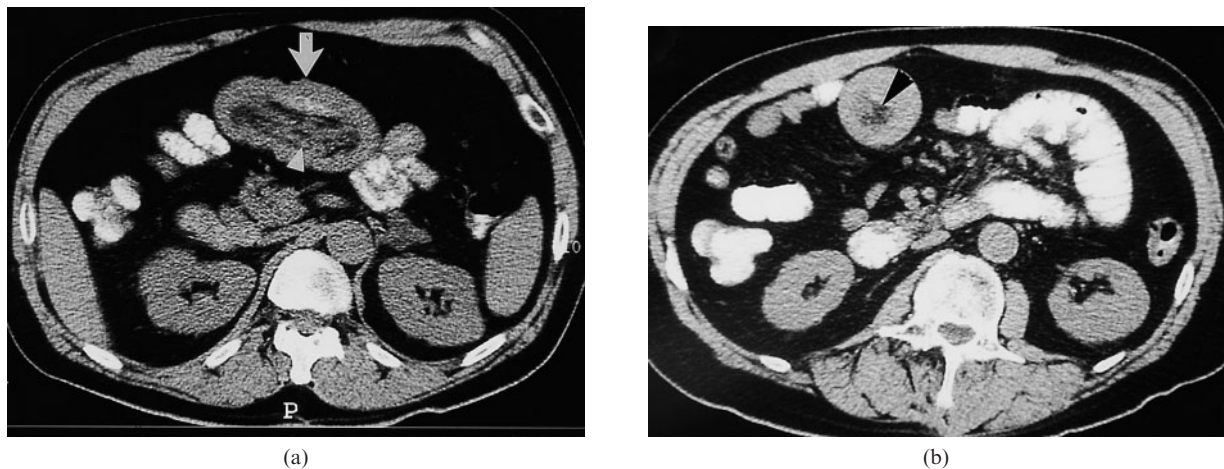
Small bowel intussusception due to a benign tumour. A 57-year-old man with recurrent abdominal pain of 1-month duration, weight loss and right upper quadrant tenderness. The intussusception appears differently relative to the slice axis. (a) An oval mass with soft tissue at its periphery (arrow) represents the bowel wall of the intussusciens and the intussusceptum, with fat density in its centre, representing mesenteric fat. Soft tissue linear densities within the mesenteric fat (arrowhead) are mesenteric blood vessels. This appearance is caused by the axis of the intussusception being parallel with the CT beam. (b) The intussusception now appears as a round mass with a “half-moon” shaped hypodense area of fat density close to its centre (arrowhead), the mesenteric fat. The beam is perpendicular to the axis of the intussusception in this more caudal section.
